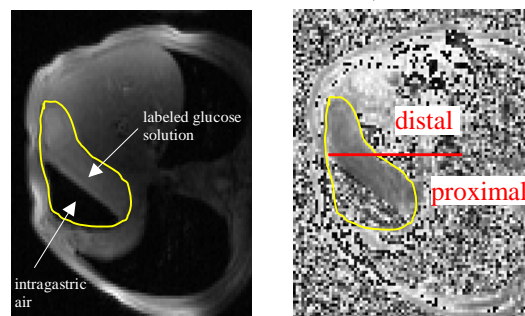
Left: Oblique coronal MR image with outlined stomach wall (yellow). Right: T1 map of the stomach.
